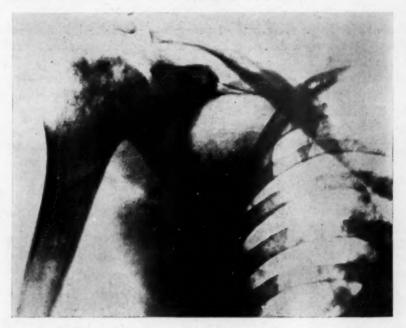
Roentgenogram of the right shoulder, taken five months before death. Evidence of a radiation osteitis may be noted in the head of the humerus, the acromium and the glenoid process.
